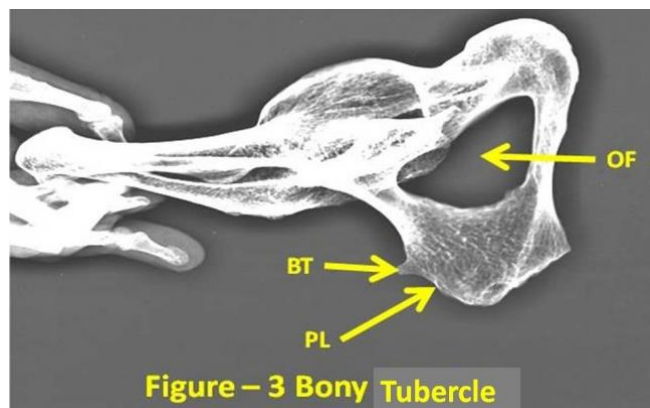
X-ray showing lateral view of hip bone displaying bony projection from pectineal line BT- bony tubercle, PL- pectineal line, OF- obturator foramen.
